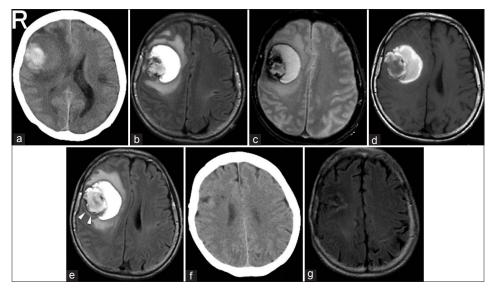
Case 3CT shows a faint hyper dense mass lesion in the right frontal lobe (a). FLAIR reveals the lesion as a mixed hypo- and hyperintensity mass with brain edema (b).T2*-weighted gradient echo imaging reveals the lesion as high intensity with low-intensity rims suggestive of hemosiderin deposition (c). Gadolinium-enhancedTI-weighted MRI shows ring enhancement (d). FLAIR imaging 2 weeks after initial MRI reveals that the lateral region of the mass has become hyperintense (arrowhead) (e). Follow-up CT and FLAIR MRI performed 6 months after surgery show no recurrence of CEIH (f,g)
